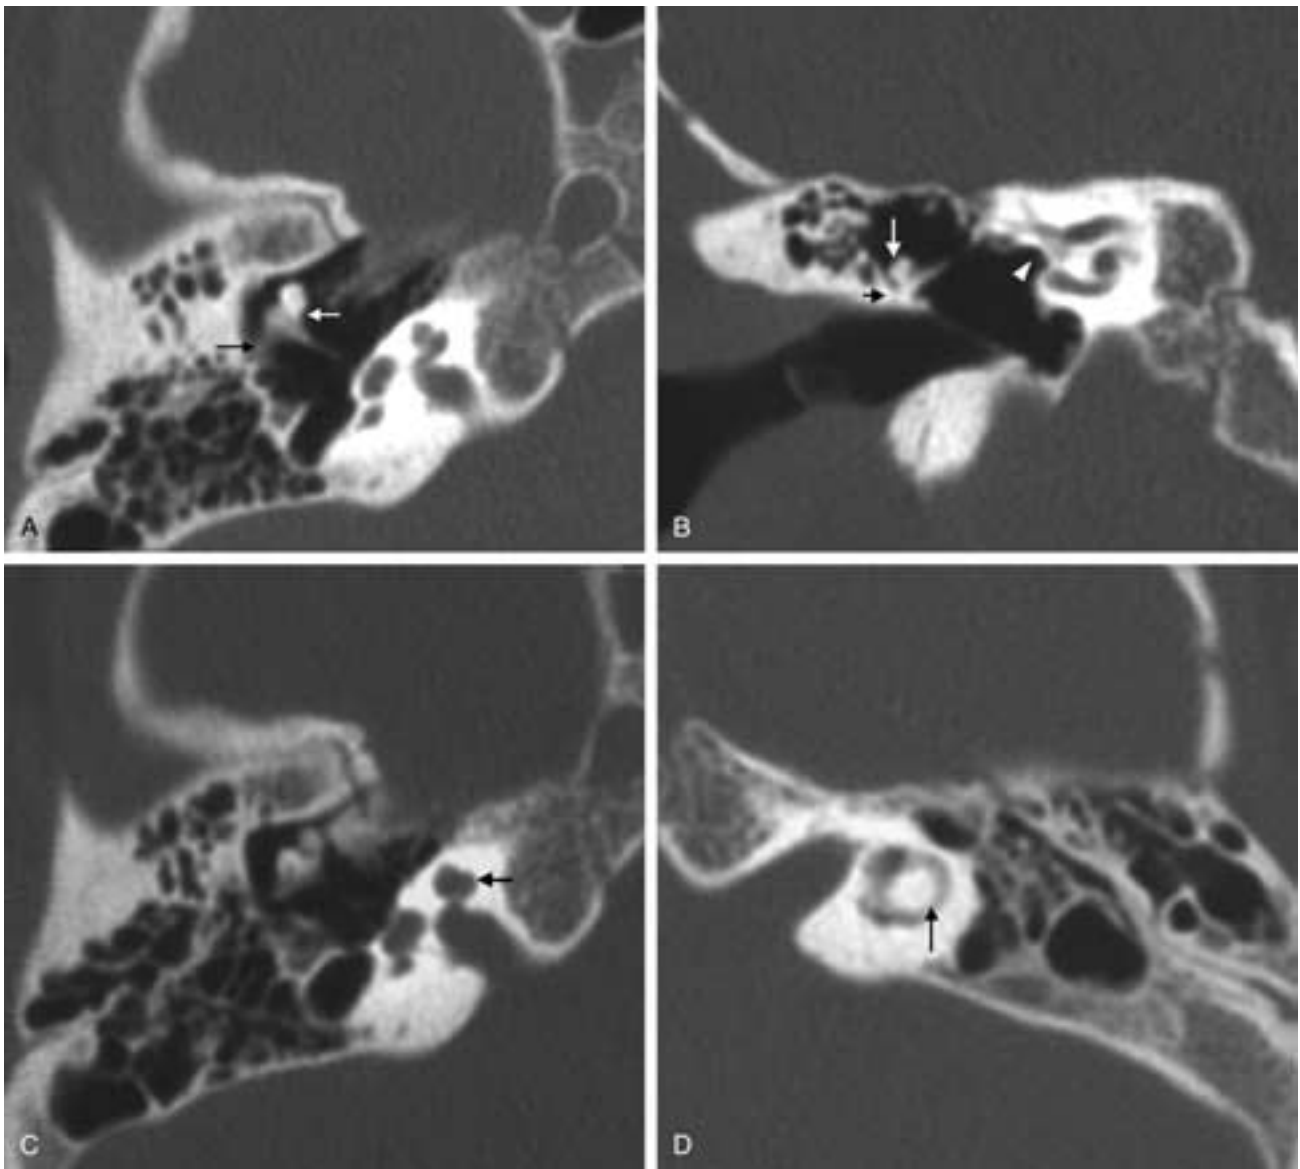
Branchio-otorenal dysplasia. A and B, Axial and coronal CT images showing a dysplastic malleus and incus (*white arrow*) with fusion to the lateral attic wall (*black arrow*). In B, note the large, deep oval window niche (*white arrowhead*). C, Axial CT image showing a hypoplastic cochlea (*black arrow*). D, Axial CT image showing a small lateral semicircular canal (*black arrow*).
